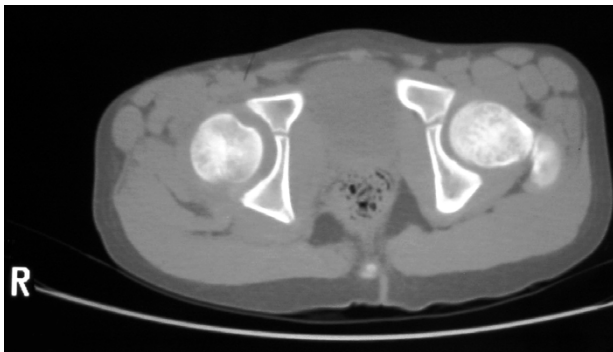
CT scan 5 days after closed reduction. Note 2–3 mm lateralization of the right femoral head, as compared to the left.
